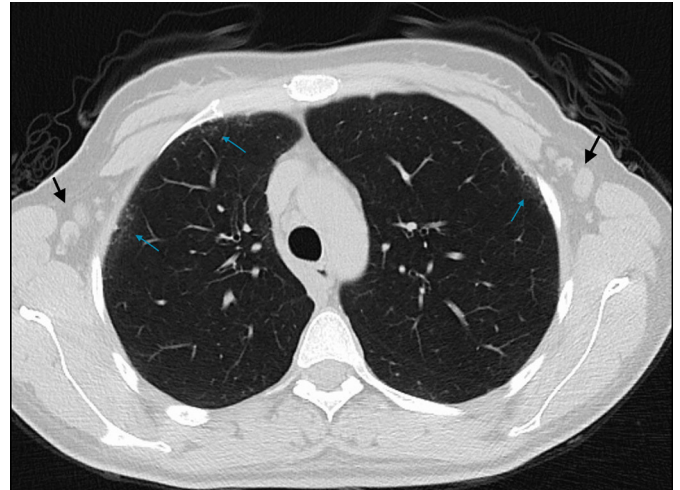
There is less reticulations in the anterior parts of the upper lobes (blue arrows) compared to the lower lobes. Axillary enlarged lymph nodes due to systemic inflammatory disease (black arrows) are observed on axial chest CT image
